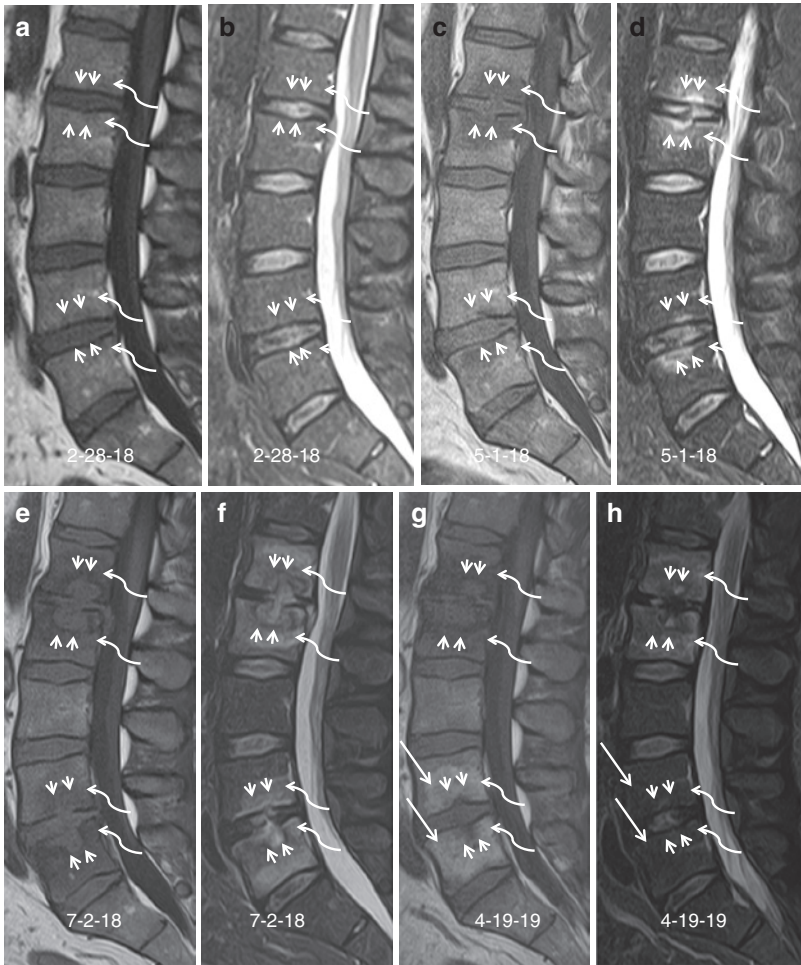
(a–f) Lateral T1-weighted (a, c, e, and g) and STIR (b, d, f and h) MR images taken from a 44 year old male before (a, b) and after (c–h) injection of autologous stem cells. The dates are displayed at the bottom of each image. Signal and endplate changes were noted at the injected L1–2 and L4–5 levels progressing from the normal pre-procedure appearance of the endplates (white arrowheads in a) and the marrow (curved white arrows in a) to erosions of the endplates best seen on the T1-weighted images (white arrowheads c, e, and g) and prominent endplate edema characterized and best seen as increased signal on the STIR images (curved white arrows in d, f, and h). The edema was first noted when the patient initially presented with pain just over 2 months after injection (curved white arrows in c and d) and the edema progressed to its maximal amount approximately 4 months after injection (curved white arrows in e and f) and began to normalize approximately 13.5 months after injection (curved white arrows in g and h) with regions surrounding the L4–5 endplate resembling Modic type 1 endplate changes (straight white arrows in g and h) with fat signal on the T1-weighted images (straight white arrows in g) which is isointense to the surrounding marrow on the STIR images (straight white arrows in h). The patient’s sed rate and C-reactive protein levels were never greater than 22 and 1 respectively and the patient was treated expectantly with medication for pain and no antibiotics due to a provisional diagnosis of non-infectious reactive changes rather than discitis primarily due to the time course of appearance of symptoms and the normal sed rate and C-reactive protein
